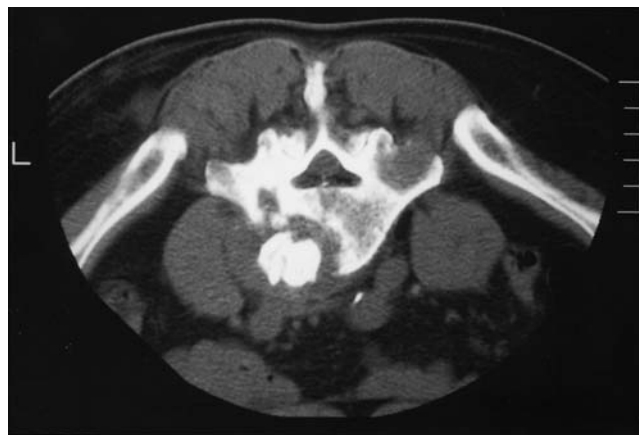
CT after PVP in Case 3 showing bone cement injected into the L5 vertebral body
